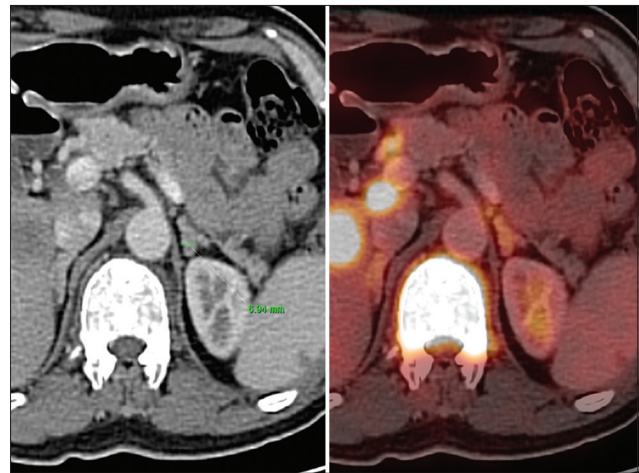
Bulky adrenal gland. Diagnosed case of a 50-year-old male having lung carcinoma computed tomography (CT) and corresponding positron emission tomography-CT images showing mildly metabolically active ( $SUV_{max}$  of 2.6) bulky left adrenal gland with retained adreniform contour
